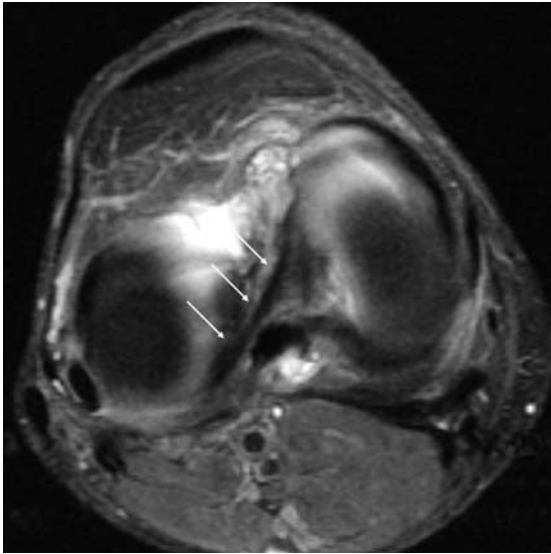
Axial TSE T2-weighted MR image of the right knee in a 38-year-old man shows the oblique meniscomeniscal ligament that runs from the anterior horn of the lateral meniscus to the posterior horn of the medial meniscus.
